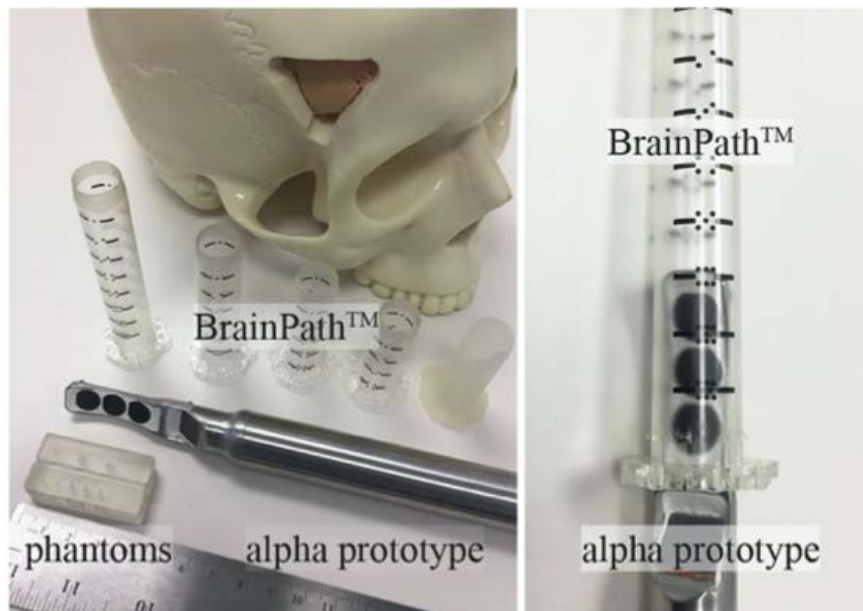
First Generation HIFU Probe: BrainPath is a Minimally Invasive Neurosurgical Toolkit, Envisioned to Host this Focused Ultrasound Device (reproduced with permission from [18])
